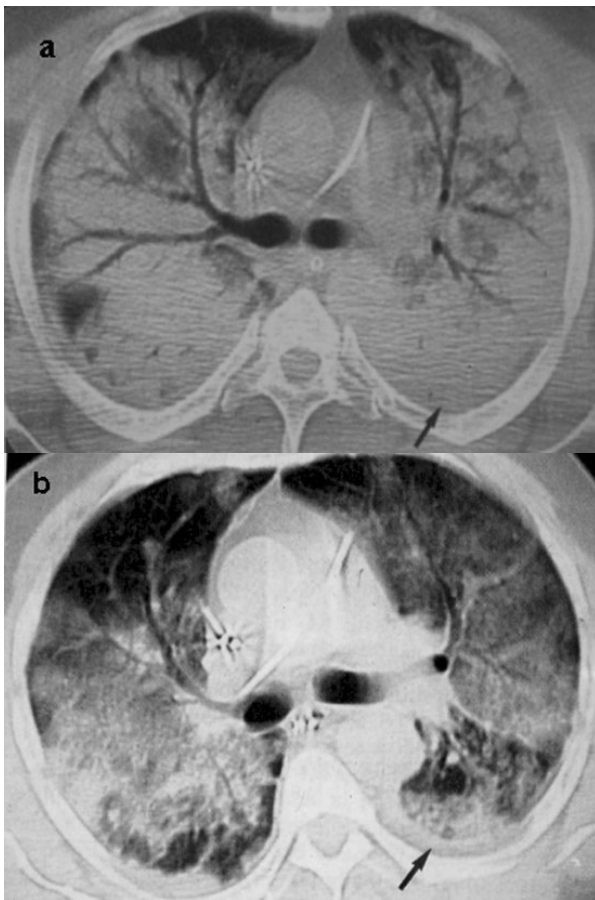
Multidetector computed tomography scan: pulmonary infiltrates (a.) and acute respiratory distress syndrome (b.).
